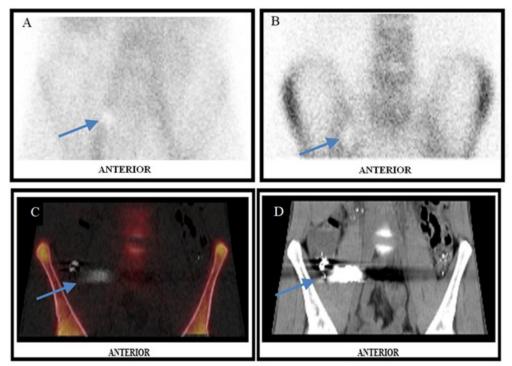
Blood pool (A) and delayed images (B) with photon deficient area (blue arrow). Plain CT of pelvis (C) and SPECT/CT images (D) revealed high density metal in the large bowel loops.
